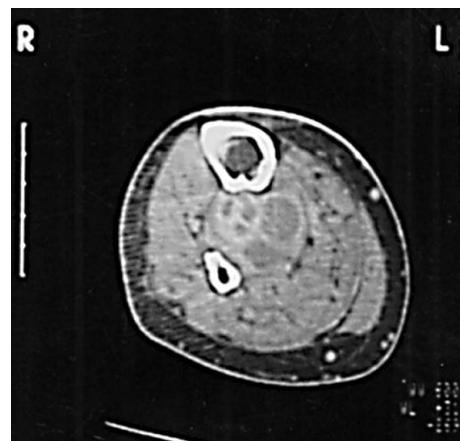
CT Scan right knee: multilocular cystic lesion.
